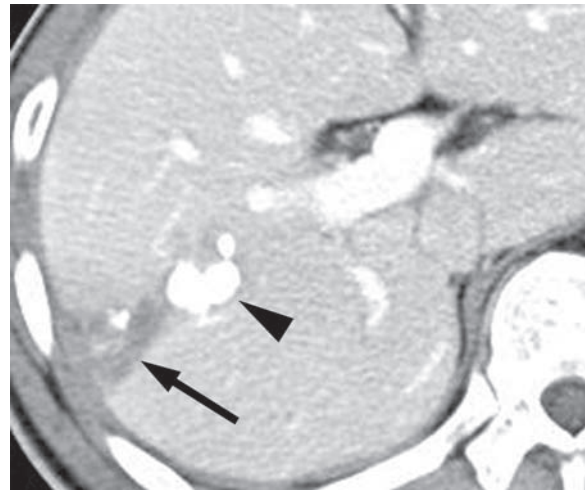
Hepatic infarction in a 53-year-old woman who had undergone transarterial chemoembolization 6 months earlier. Contrast-enhanced CT scan shows a wedge-shaped hypoattenuating lesion (arrow) extending to the liver surface peripheral to embolized hepatocellular carcinoma (arrowhead).
